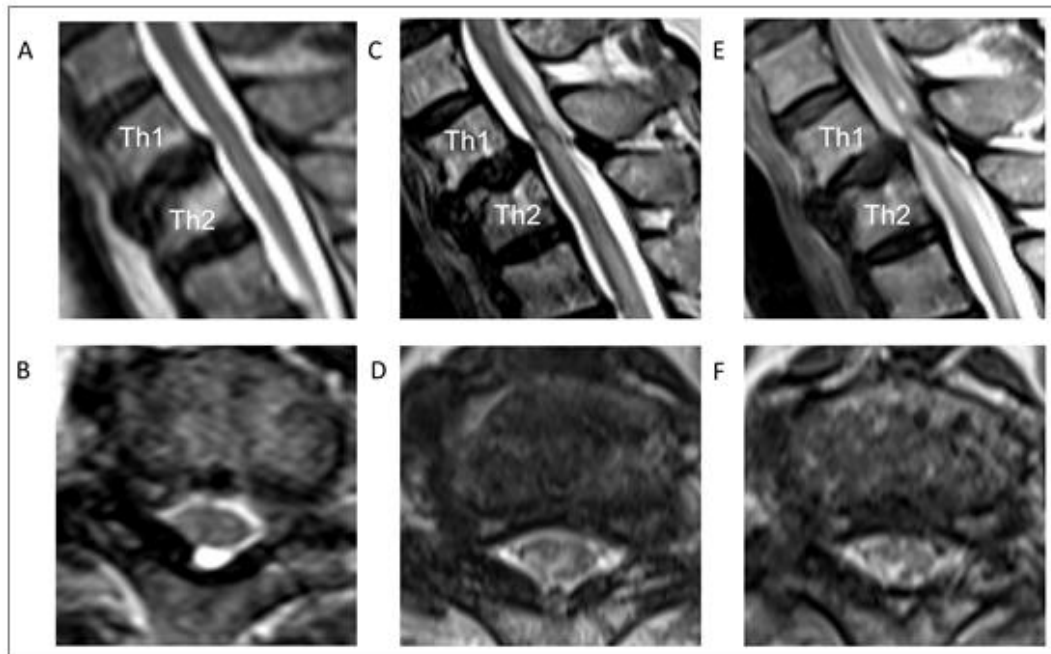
Time dependent change of MRI of the thoracic spinal cord. T2-weighted images.
